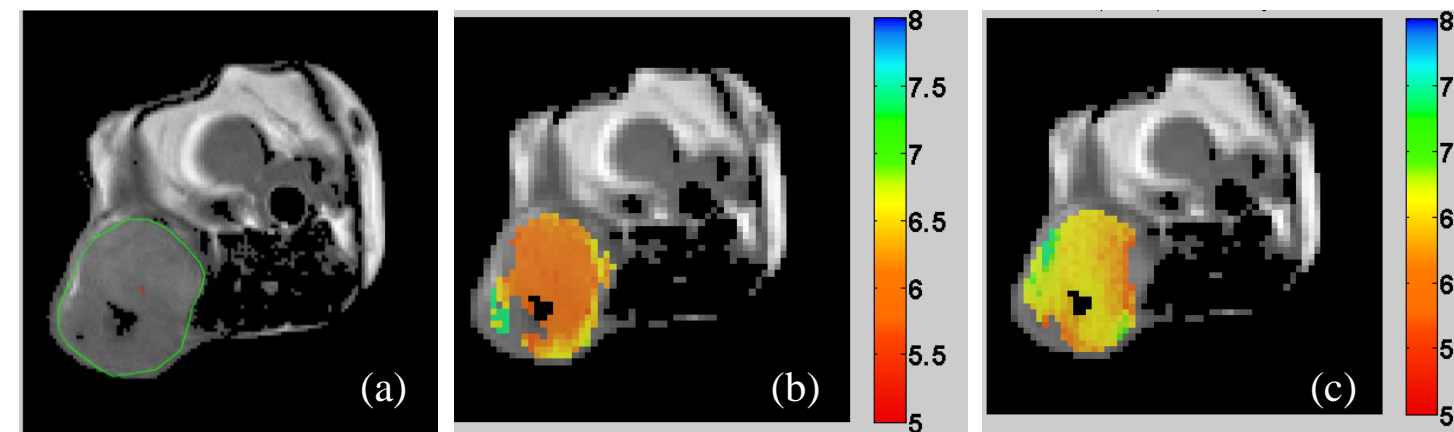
CEST MRI of iopamidol for pH imaging [1] of a Panc02 clone 38 SC tumor. (a) T2 weighted image, (b) CEST MRI before L-DOS47 injection, (c) ~30 minutes after 90 µg/kg L-DOS47 injection. The difference in mean pHs is 0.38 units. L-DOS47 was administered iv. Iopamidol was administered SC, next to the tumor.
